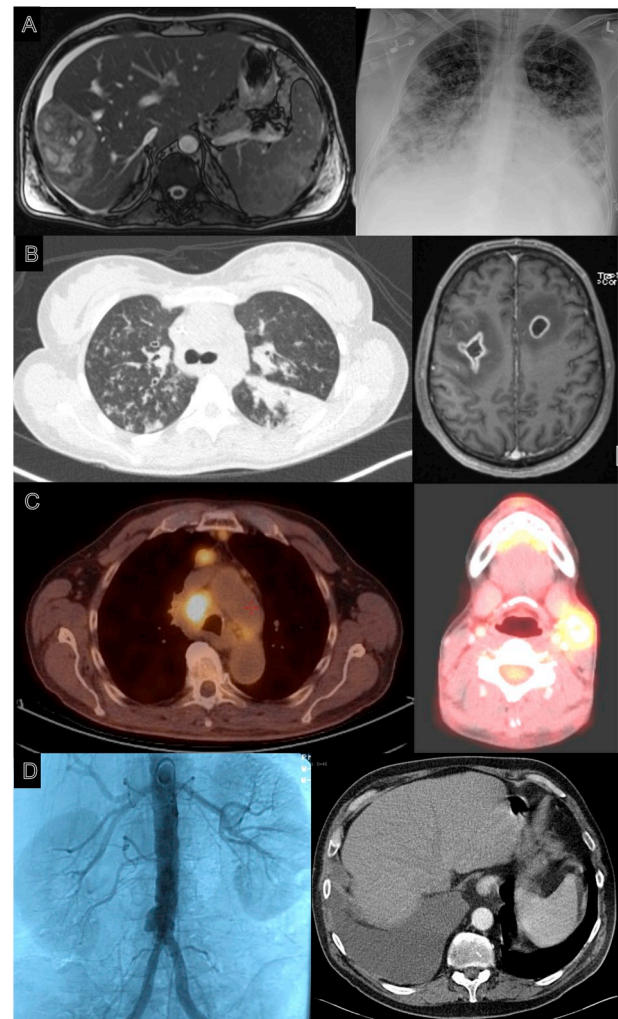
Radiological manifestations of melioidosis in returned travelers. A (left): Characteristic magnetic resonance imaging (MRI) image of a 46-year old male showing an area of partly hyper-intense signal intensity in the liver suspected for a liver abscess (case no. 14). A (right): Chest X-ray of the same 46-year old patient showing extensive bilateral consolidations suspect of bilateral pneumonia. B (left): Computed tomography (CT) scan of a 21-year old female with cystic fibrosis showing multiple pulmonary consolidations suspect of lobar pneumonia and bronchial tree-in-bud opacities (case no. 11). B (right): Characteristic MRI image of a 49-year old male depicting two brain abscesses with edema (case no. 9). C (left): ¹⁸F-fluorodeoxyglucose (18F-FDG) positron emission tomography-CT (PET-CT) scan of a 69-year old male; note the mediastinal/hilar lymphadenopathy (images of first episode; case no. 3). C (right): PET-CT image of a 30-year old female revealing intense uptake in the neck on the left side suspected for a neck abscess with a “cold” area, highly suspicious for central necrosis (case no. 13). D (left): Aortic angiography of a 61-year old male showing a mycotic aneurysm of the distal abdominal aorta (case no. 30). D (right): Characteristic CT scan image with intravenous contrast of a 57-year old male showing extensive pleural fluid on the right side (case no. 19). See [Supplementary Table S2](#) for details of cases.
